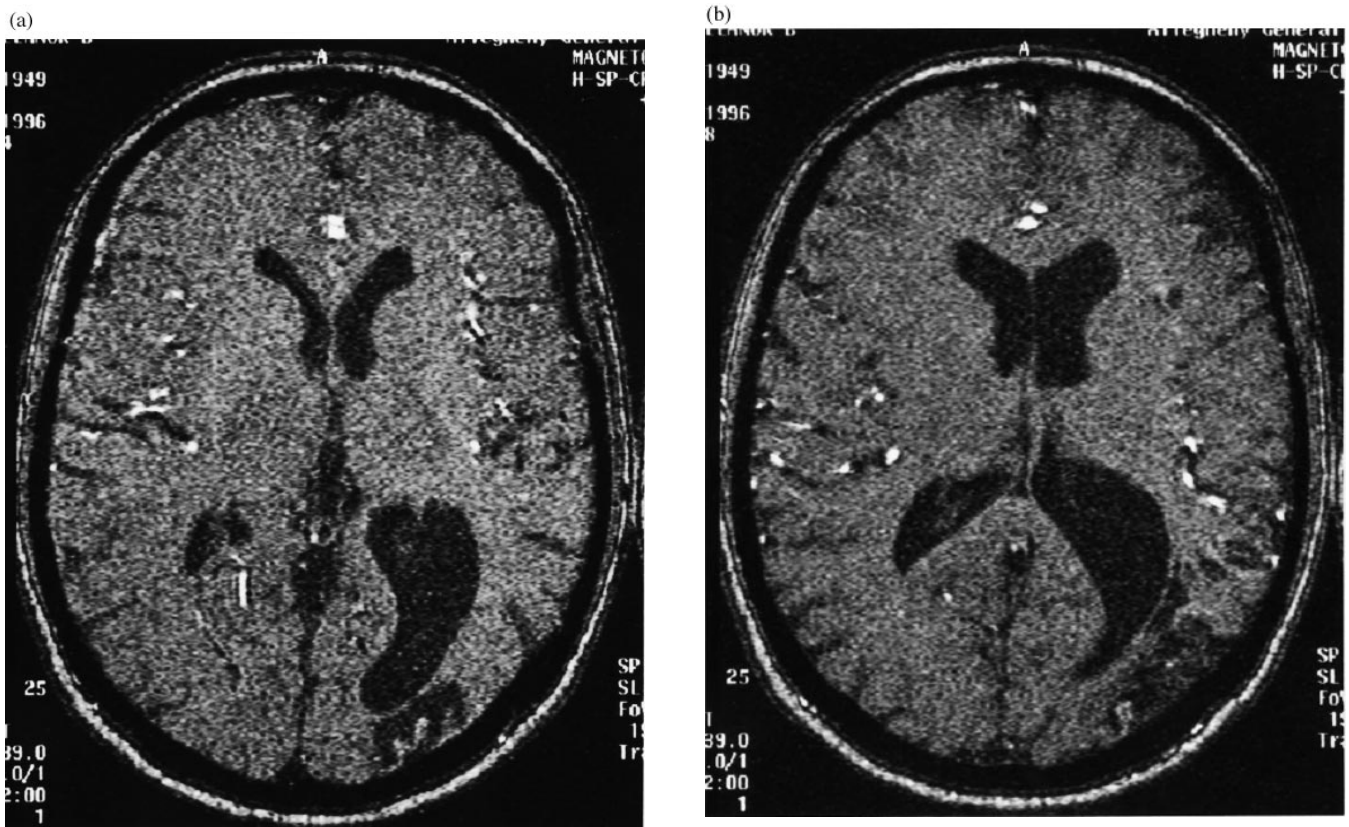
Two slices from the MRI scan for patient EL showing extensive occipitotemporal lobe involvement on the left (see text for further details).
